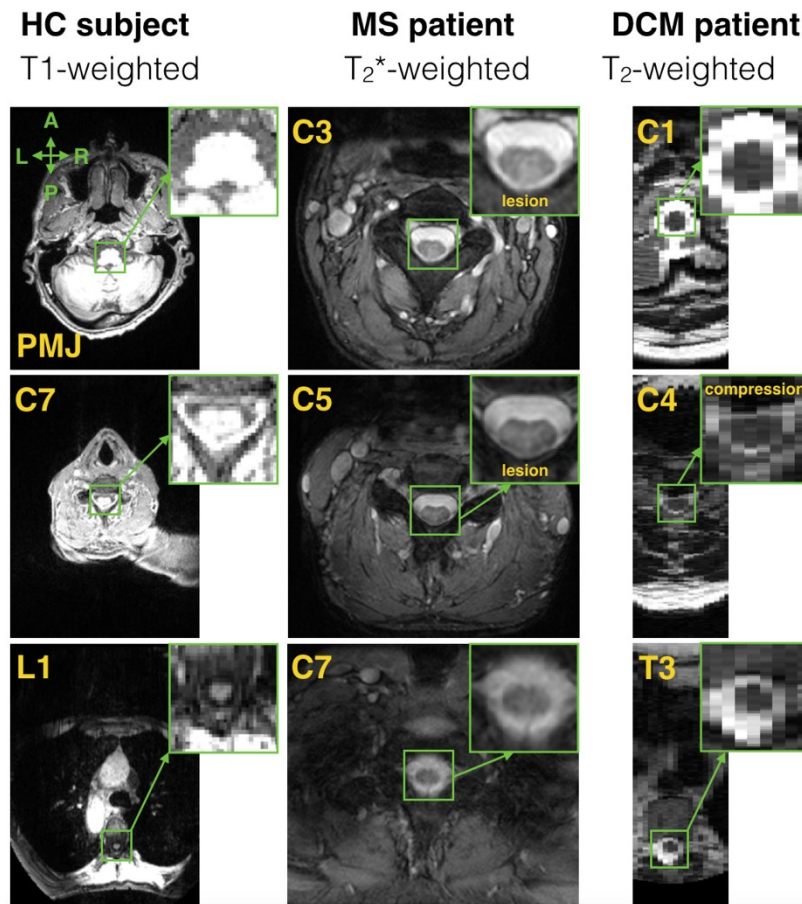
Samples of spinal cord MRI data in the cross-sectional plane.
